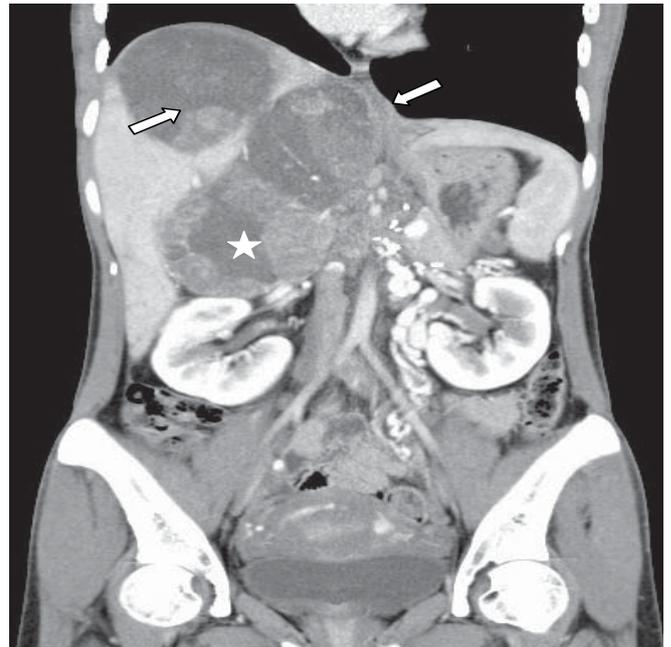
Coronal image of contrast-enhanced CT 1 year later demonstrating multiple well-circumscribed lesions in the right suprarenal (5-pointed star), and two of the liver metastases within segment VIII and segment IV (white, block arrows). The lesions are generally solid with necrotic/cystic areas within. Surgical clips from previous surgery are seen in the left suprarenal surgical bed which is free of tumor recurrence.
